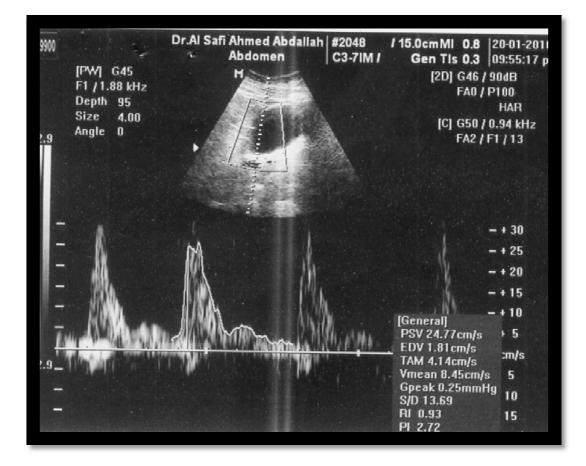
color Doppler scans 35 old patient (RPL) showing incomplete abortions.
